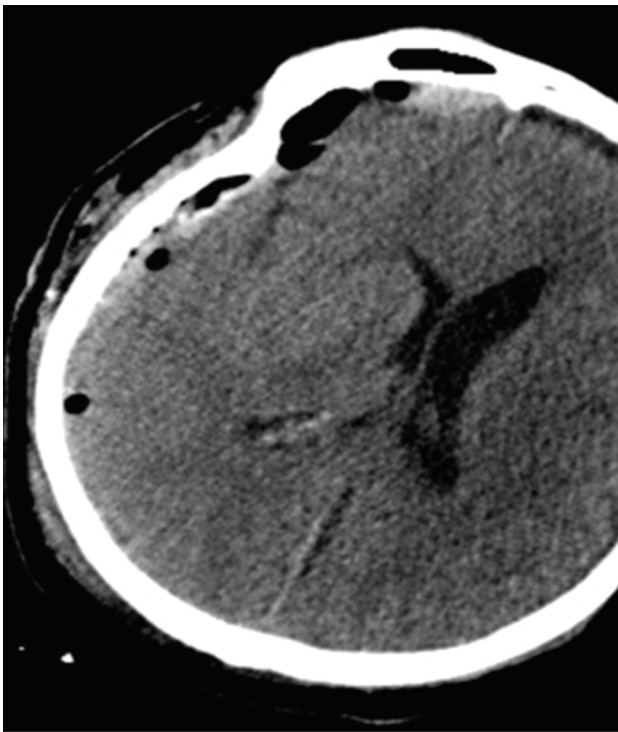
Postoperative CT showing evacuation of the hematoma and resolution of the midline shift.
